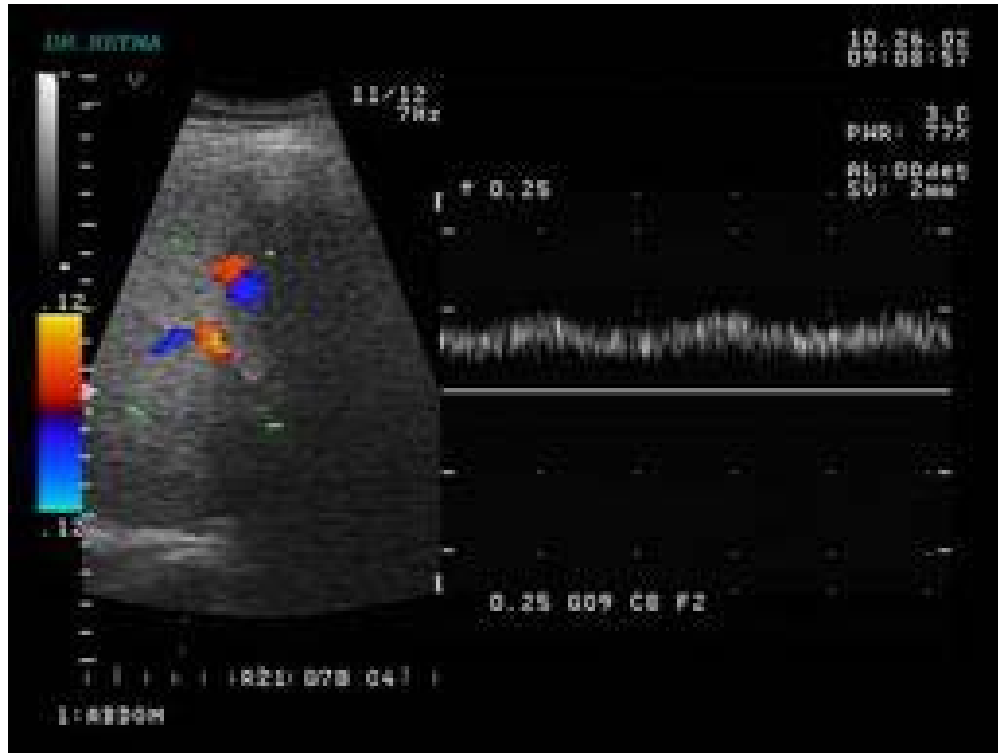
Colour doppler shows normal portal venous spectral waveform.
